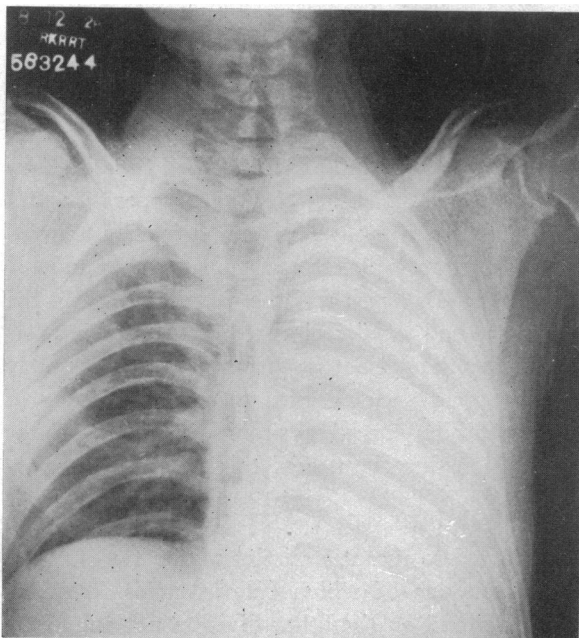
Initial roentgenogram showing massive collapse of the left lung and marked displacement of the heart and mediastinum.
